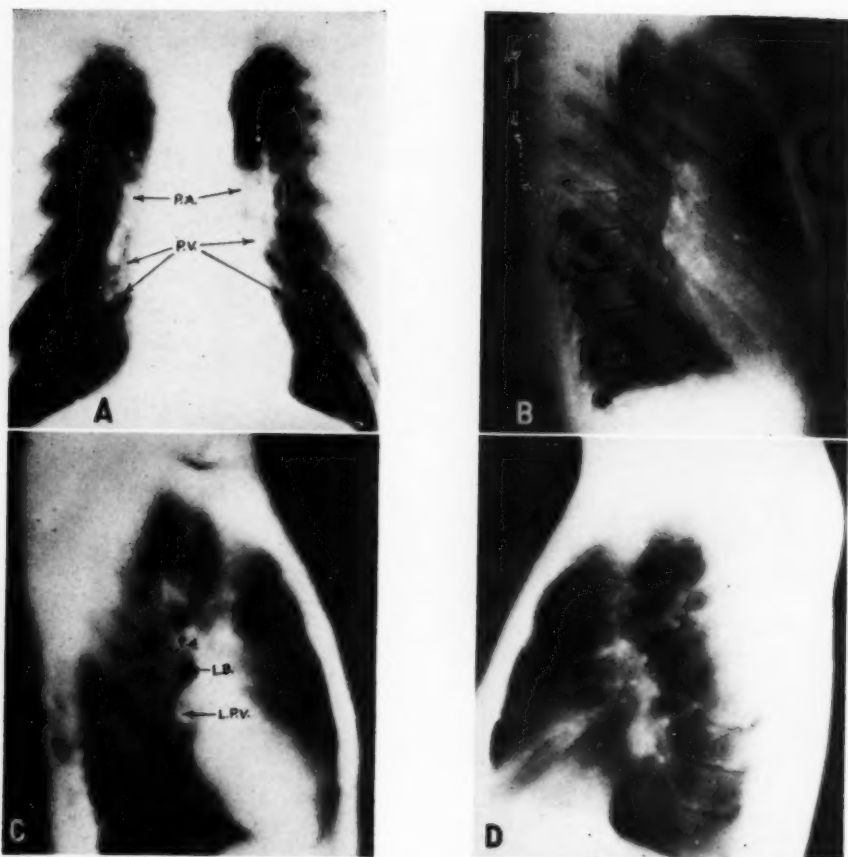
Pulmonary arteries and veins as visualized by sectional radiography in a healthy adult.
